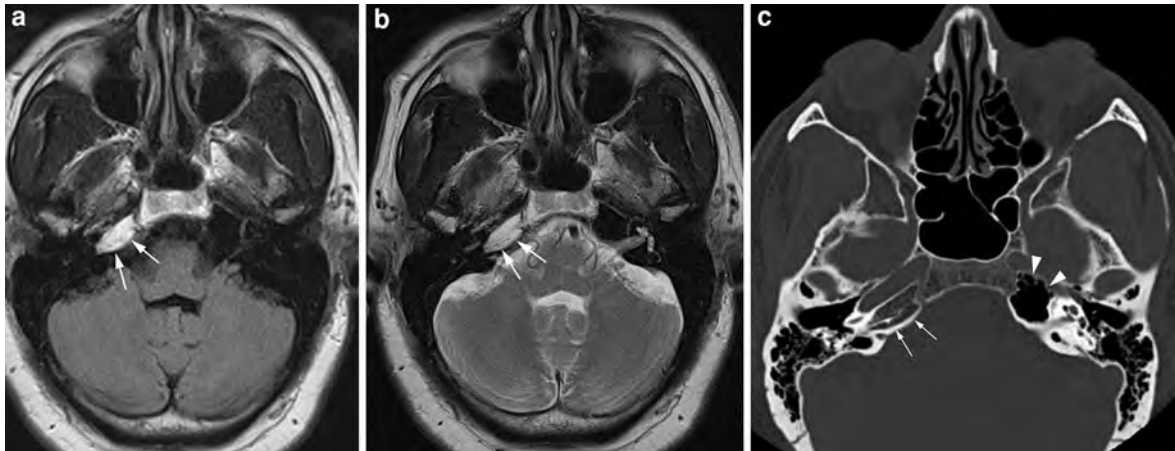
Axial non-contrast enhanced T1- (a) and T2-weighted (b) images demonstrate increased signal intensity within the right petrous apex (arrows in a and b) that is often mistaken for a small cholesterol granuloma. The axial CT image displayed in bone window however, reveals the true nature of this “lesion” as it shows preserved diploic trabeculations within
